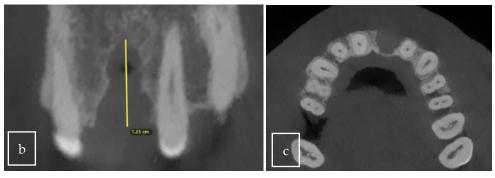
(a) Three-dimensional examination. (b,c) Pre-operative CBCT scan showing axial (left) and transversal (right) views.
